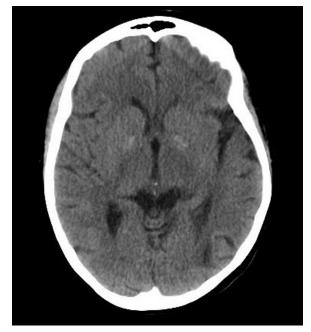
Brain CT showed faint SLE related vasculitis/vasculopathy of the intracranial vessels
